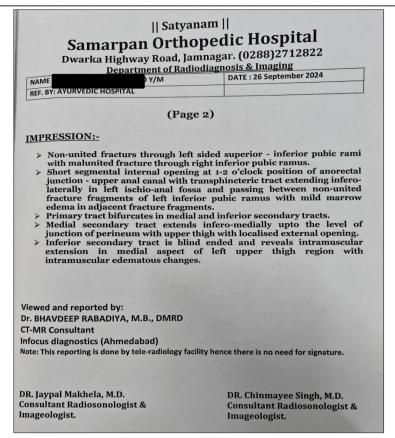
2.2 MRI of Perianal Region
